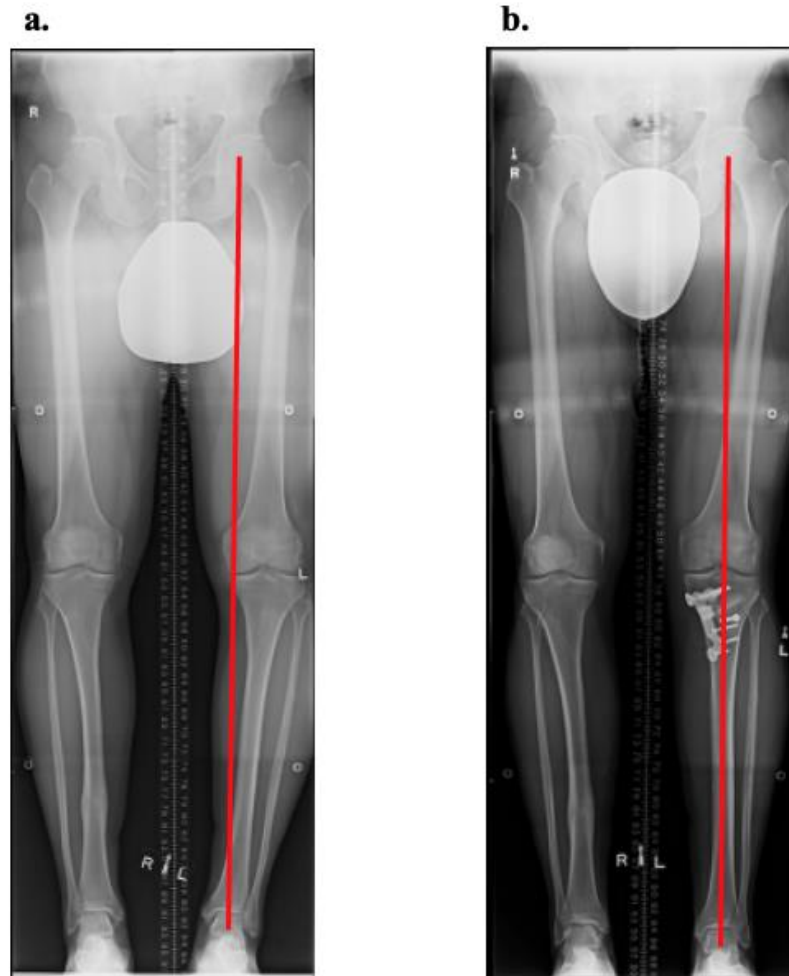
Patient radiographs a. before and b. 12 months after MOWHTO. The red line depicts an estimate of the weight bearing line that displays a shift to neutral after MOWHTO.
